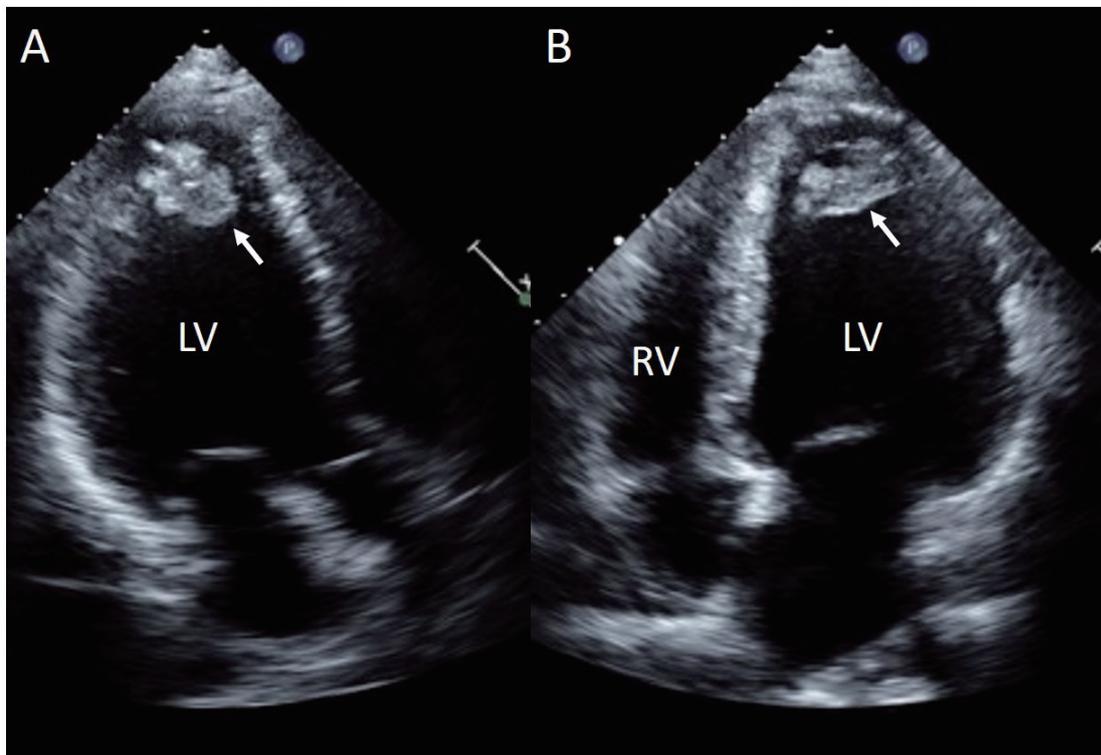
Apical long axis (A) and 4-chamber (B) views by transthoracic echocardiography show a left ventricular thrombus at the LV apex (arrow). LV, left ventricle; RV, right ventricle.
